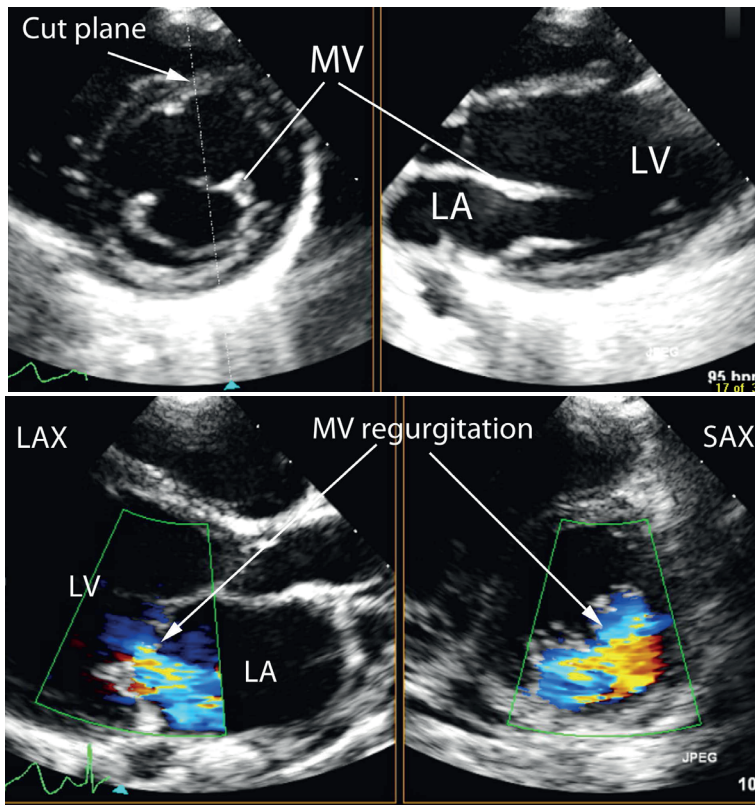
Cross-plane imaging. (A) Cross-plane imaging of the mitral valve by transthoracic echocardiography showing the user defined cut plane (dotted line and triangle) to show a short-axis view of the mitral valve (left panel) and the corresponding long-axis view (right panel). (B) Cross-plane imaging of mitral valve regurgitation which permits precise localisation of regurgitant jets in the long-axis (left panel) and short-axis views (right panel). The cut plane is indicated by the triangle. LAX, long axis; SAX, short axis; LV, left ventricle; LA, left atrium; MV, mitral valve.
